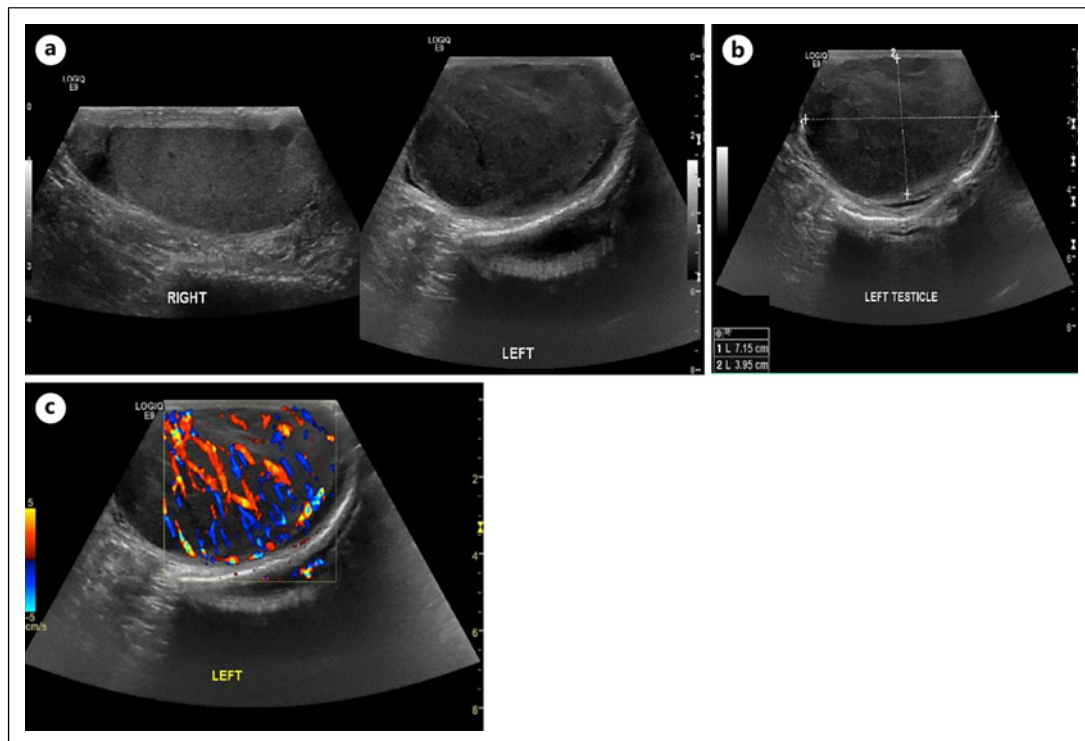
a Ultrasound of the scrotum/left testis showing discrepancy in size and echogenicity of both testes with significantly enlarged left testis. The testis had a heterogeneous tissue matrix with predominantly hypoechoic with a maximum size of 7.2×3.9 cm (b) and had markedly increased vascularity on color Doppler study (c).
